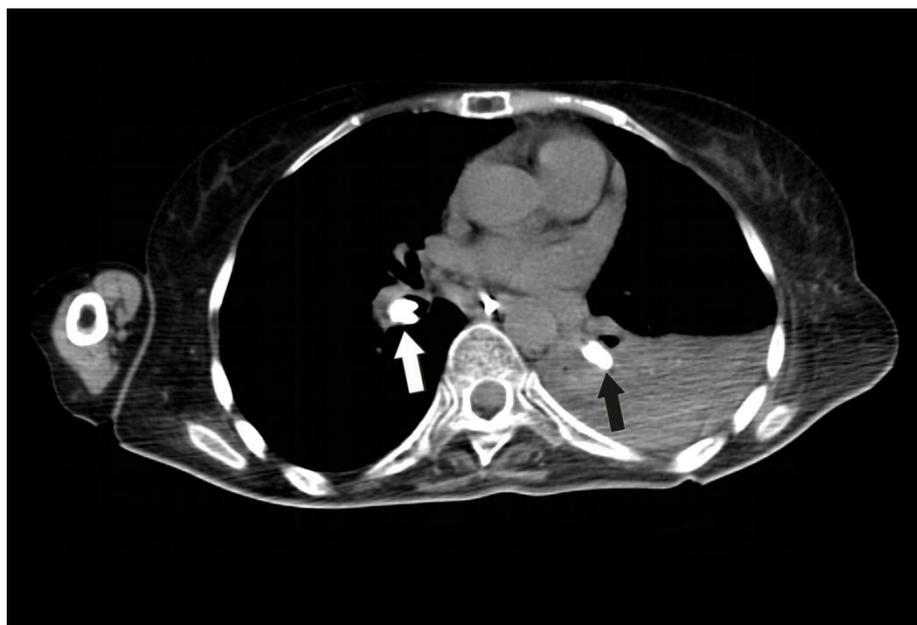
Non contrast CT examination confirmed that there are molar teeth in main bronchi.
